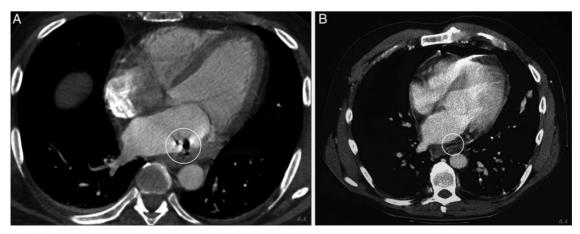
CT scan. (A) Contrast-enhanced chest CT scan shows a bubble of air in the LA and a smaller amount of extra cardiac air along the anterior wall of the oesophagus consistent with an AOF. (B) CT scan of the chest revealed air and fluid in the pericardium anterior to the oesophagus. LA: left atrium; CT: computed tomography; AOF: atrio-oesophageal fistula.
